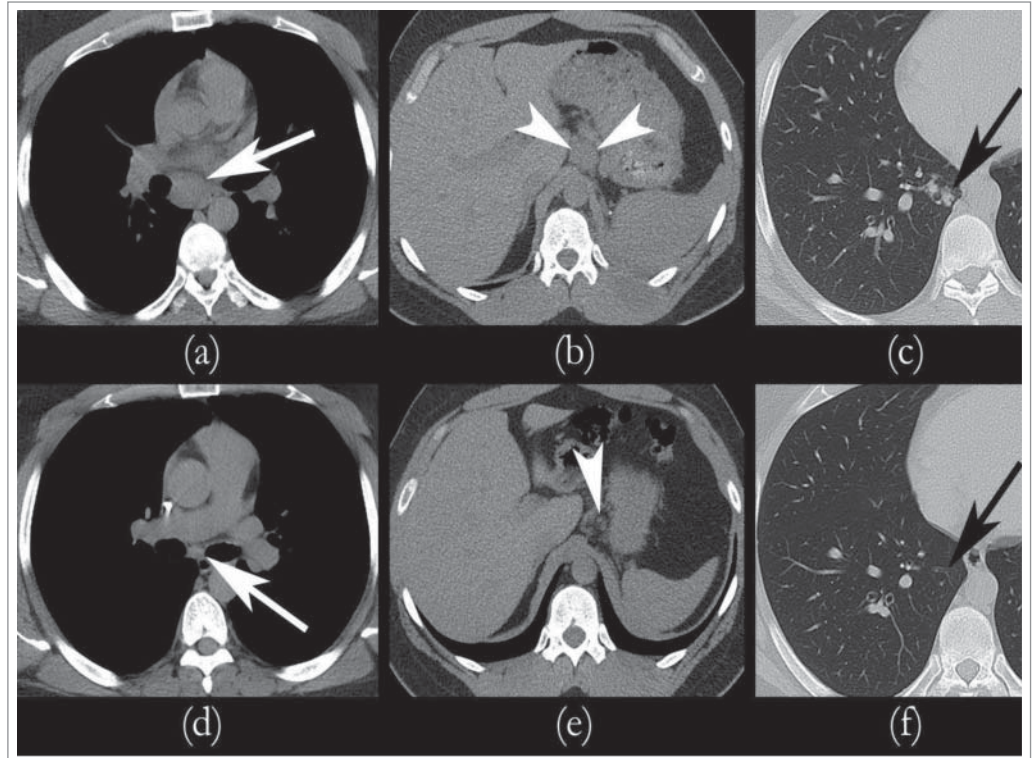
Sequential CT scans showing response to therapy. Metastatic Renal Medullary Carcinoma with Complete Remission of Disease post chemotherapy and it remained the same while on maintenance: CT scan prior to the initiation of chemotherapy revealed significant lymphadenopathy consistent with metastatic disease in the mediastinum (A), gastrohepatic ligament (B), and in the right lung (C). After Cycle 4 of chemotherapy, CT imaging revealed complete remission of mediastinal (D), gastrohepatic ligament (E), and pulmonary (F) nodules.
